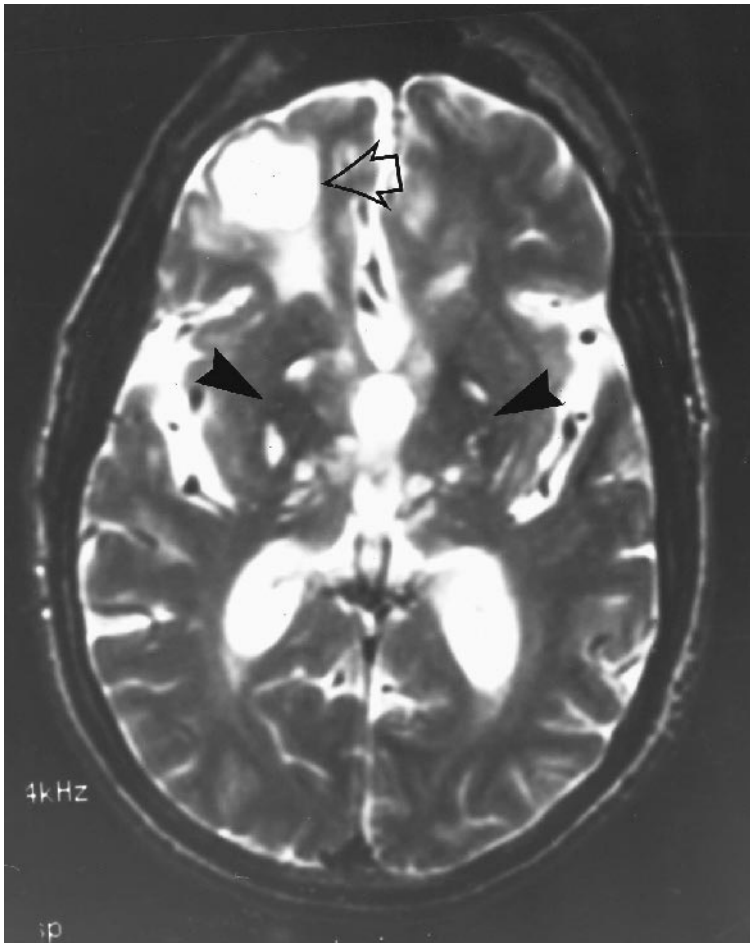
Multiple lacunar infarcts. Axial T₂ weighted magnetic resonance imaging sequence demonstrates multiple rounded areas of high signal intensity within the basal ganglia and thalamus (arrowheads). There is also an old infarct in the right frontal region (hollow arrow).
